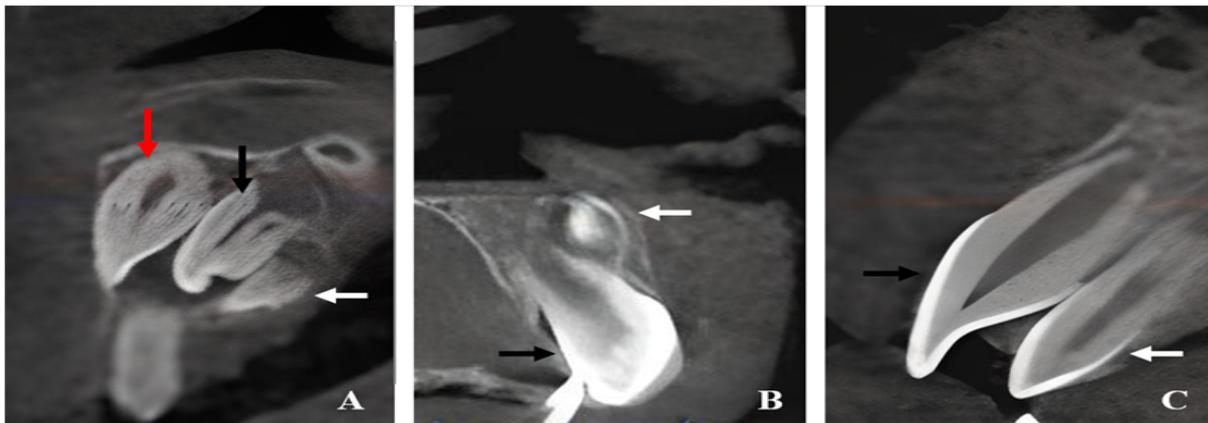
A. CBCT image of the patient with a D score. Red arrow: Upper lateral incisor tooth, Black arrow: Upper santral incisor tooth, White arrow: Mesiodens. B. CBCT image of patient with an E score; Black arrow: Upper santral incisor tooth, White arrow: Mesiodens. C. CBCT image of patient with a G score, Black arrow: Upper santral incisor tooth, White arrow: Mesiodens.
